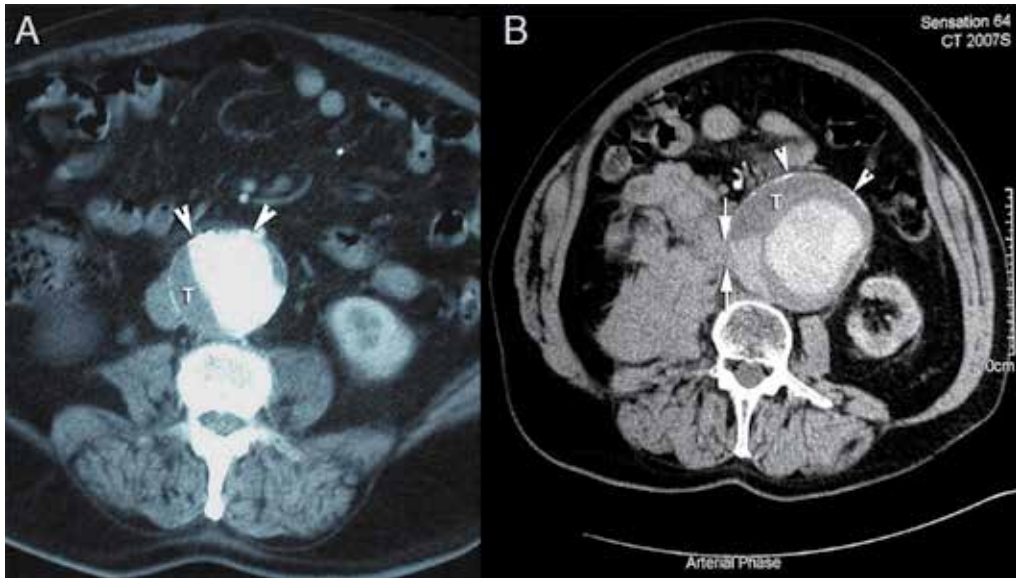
Computed tomography of a (A) 6.5cm AAA in a 74-year old male and (B) ruptured 8.3cm AAA in a 79-year old male. The anterior aneurysm wall is calcified (arrowheads) in both cases. Notice the effect of adherent intraluminal thrombus (T) on total wall thickness. (B) the posterolateral (retroperitoneal) rupture site (arrows). This is a common site for AAA rupture.
